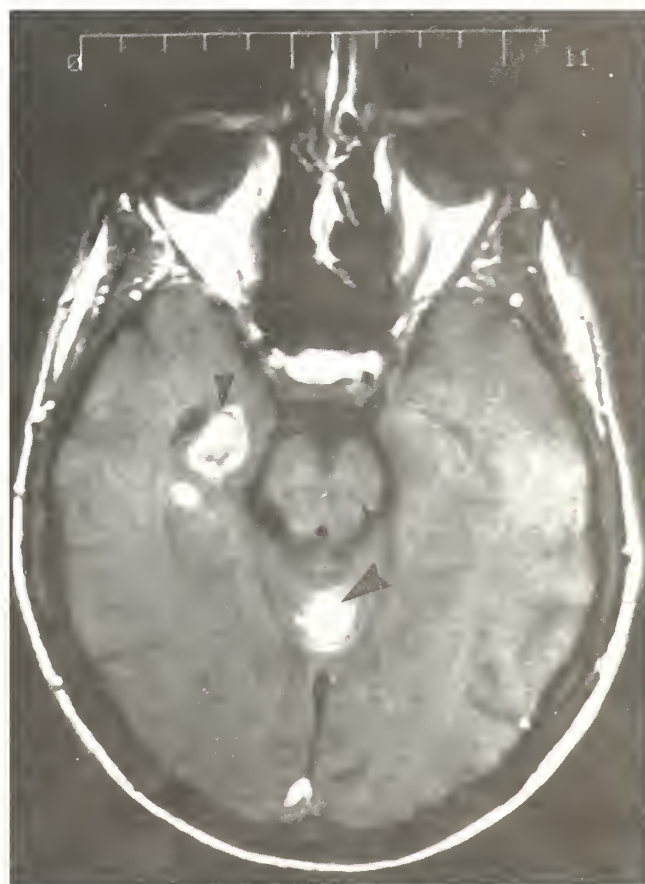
Thirty-five-year-old man with primary CNS lymphoma proven by biopsy. Gadolinium-enhanced axial T1-weighted image demonstrating lesions in the right hippocampus (small arrow) and cerebellar vermis (large arrow).
